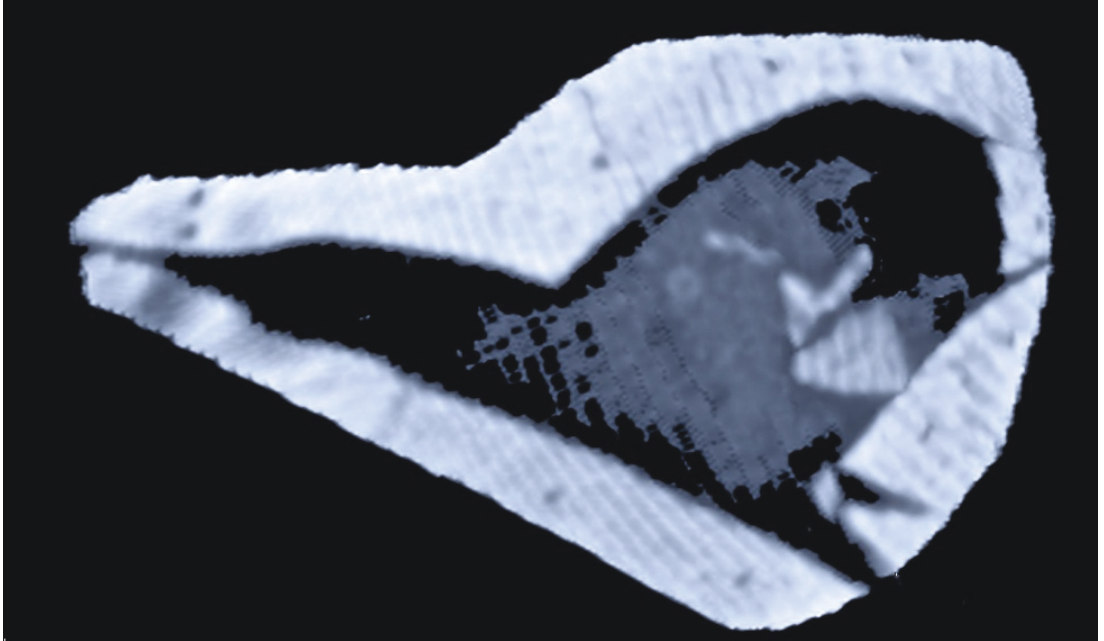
Early mineralisation observed at one-week postoperative 3-D CT.
